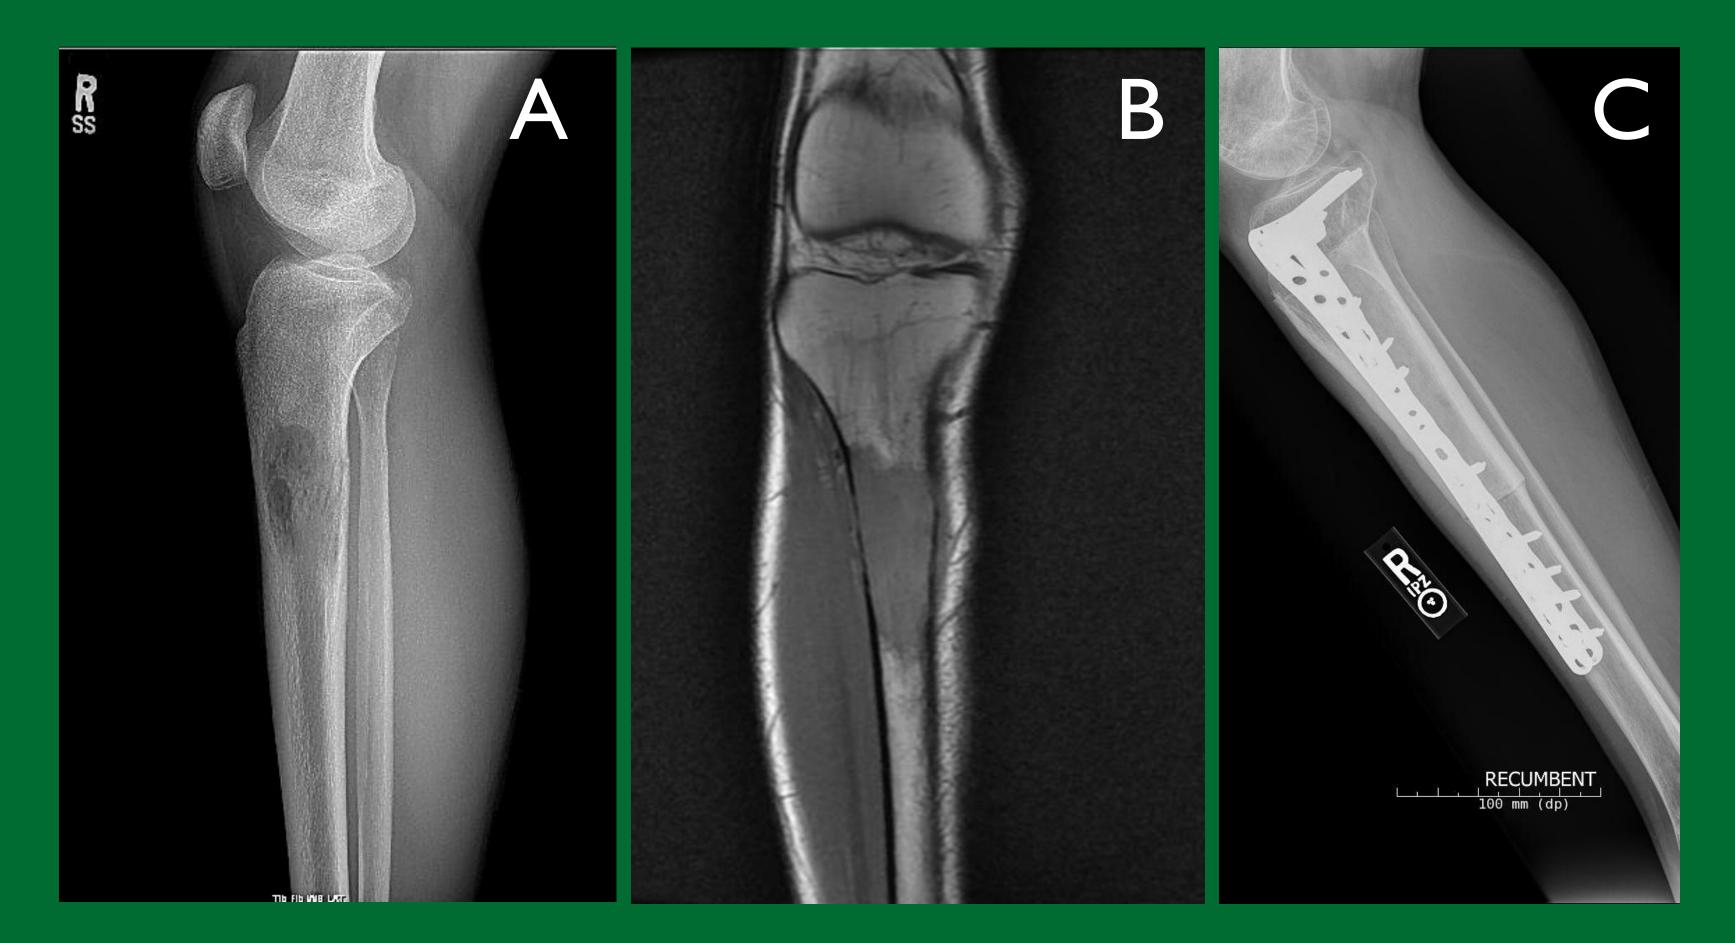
Case 4: Preoperative radiograph (A) and MRI (B) and postoperative lateral radiograph (C) showing bridging plate osteosynthesis going on to union.
